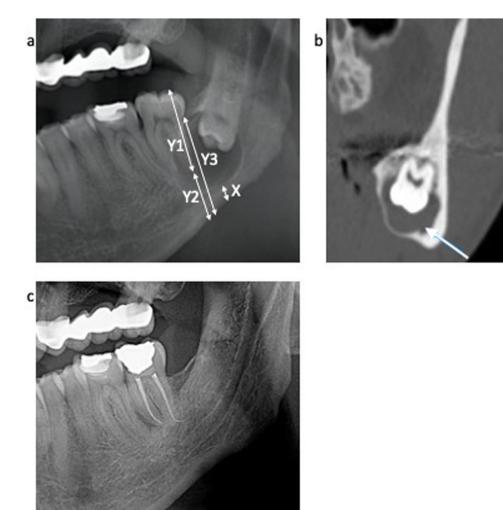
Panoramic and CT images of an included case. (a) Panoramic radiographic view indicating the height of mandibular canal (X), the reference lengths (Y1: the distance between the tip of the cusp and the apex of the reference tooth adjacent to the lesion, Y2: the distance between the apex of reference tooth and mandibular lower border, and Y3: the distance between the distal cementoenamel junction of the reference tooth and mandibular lower border) preoperatively. (b) The displaced mandibular canal on CT view. (c) Panoramic radiographic view indicating the relocation of mandibular canal postoperatively.
